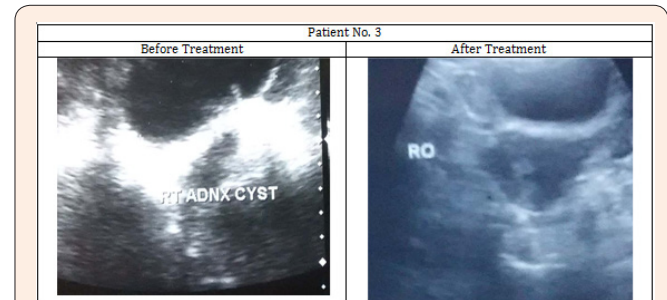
Images of Ultra-sonography of the patient No. 3 showing removal of the cyst from right ovary.
